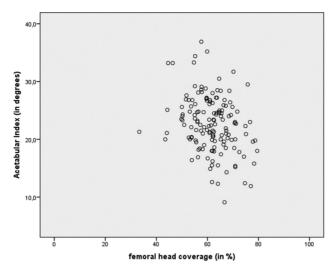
Correlation between acetabular index in radiographs and femoral head coverage in ultrasounds.
